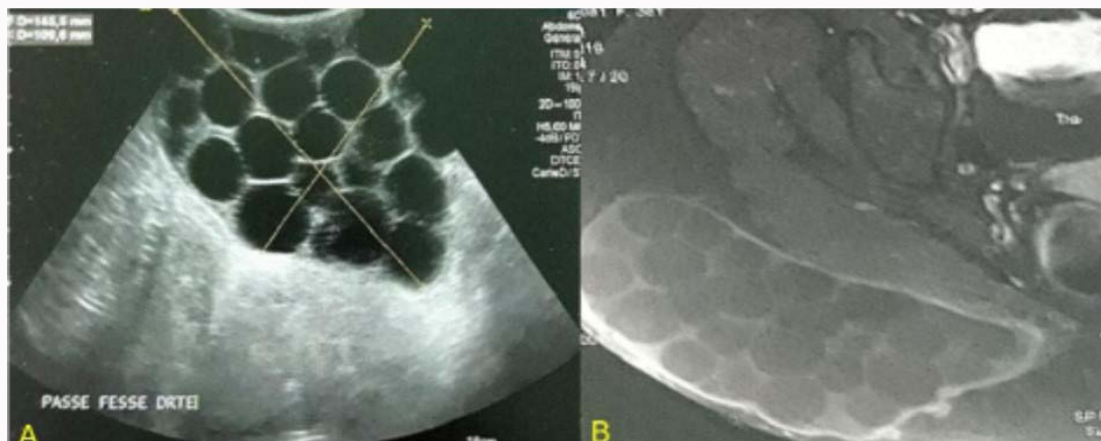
Ultrasound view and MRI in axial section of the T2 gluteal region showing a type III hydatid cyst.
